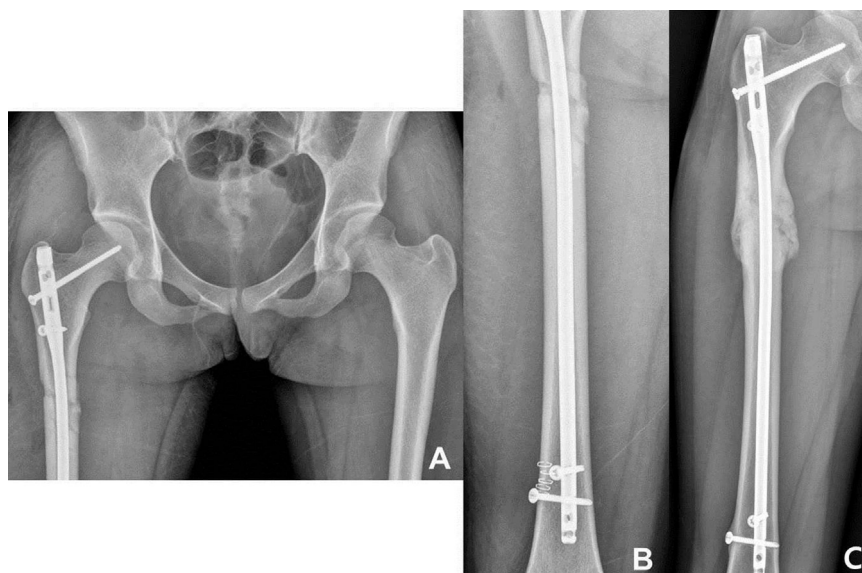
Postoperative radiographs show well-positioned expert tibia nail greater trochanter was used as an entry point and one locking screw was inserted into the femoral head (A and B). After 8 months of operation, radiographic union was obtained (C).
